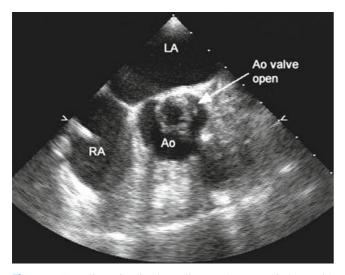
Two dimensional echocardiogram (parasternal short axis) demonstrates an uncuspid and thickened aortic valve
